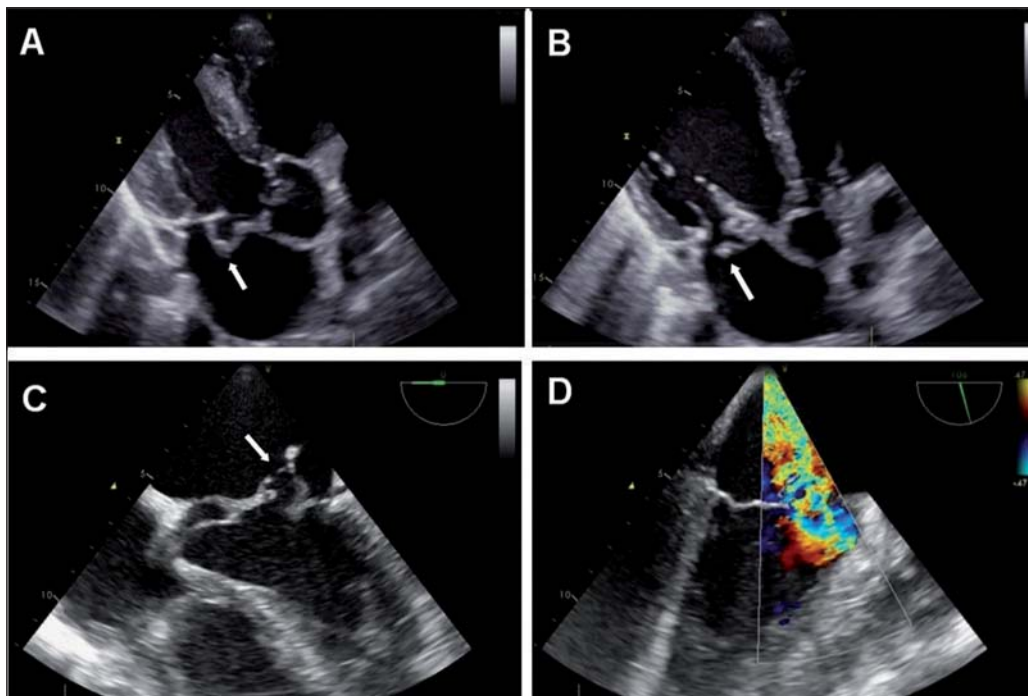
(A) Transthoracic echocardiography: aneurysm of the anterior mitral leaflet (arrow). (B) Transthoracic echocardiography: nodular image compatible with small vegetation (arrow). (C) Transesophageal echocardiography: aneurysm and perforation of anterior mitral leaflet (arrow). (D) Transesophageal echocardiogram: severe mitral regurgitation.
